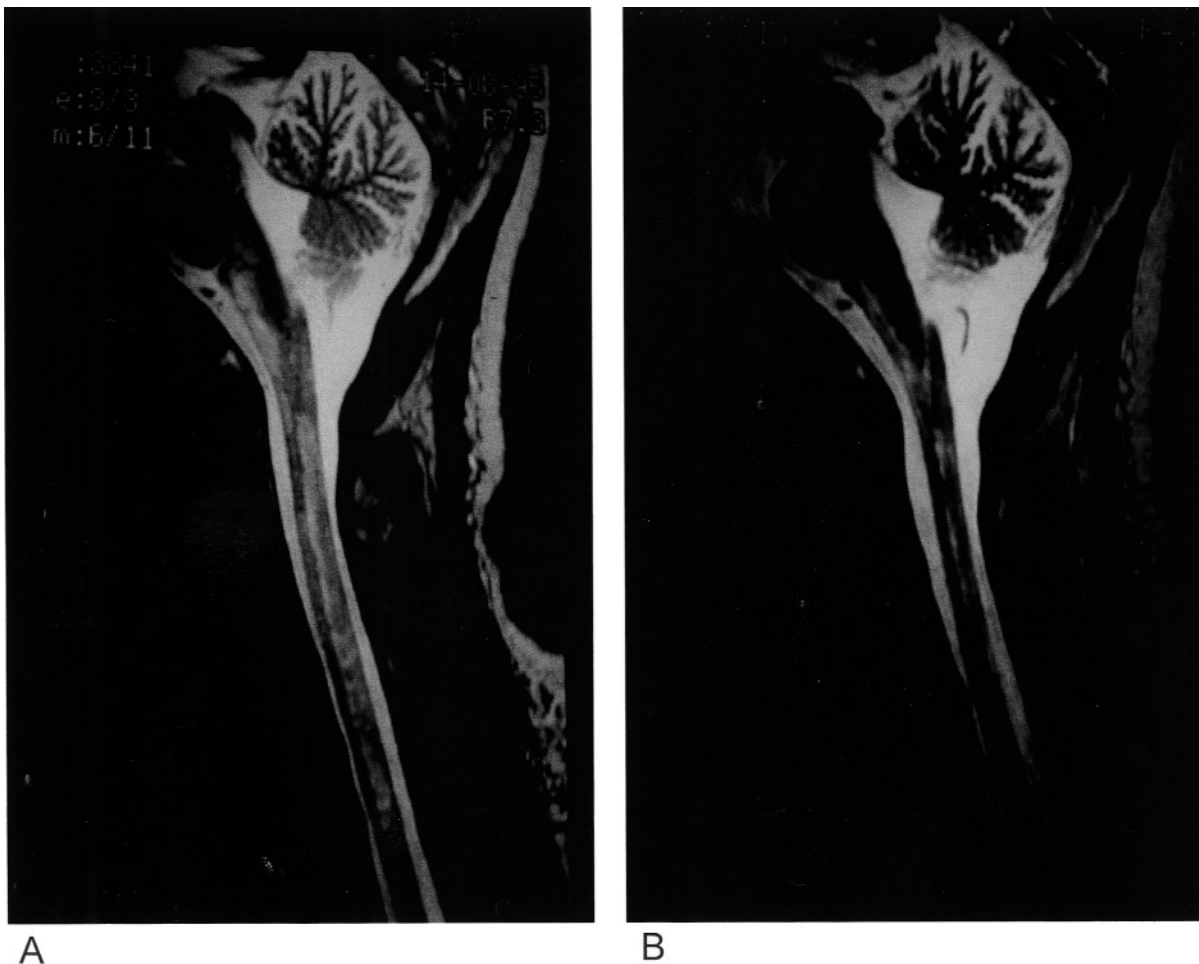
A. T2 weighted MRI of Patient 1 showing extensive high signal lesions with marked edema of the cervical cord. B. T2 weighted MRI 4 months later shows resolution of edema and improvement in high signal lesions after intravenous methylprednisolone and cyclophosphamide followed by azathioprine.
